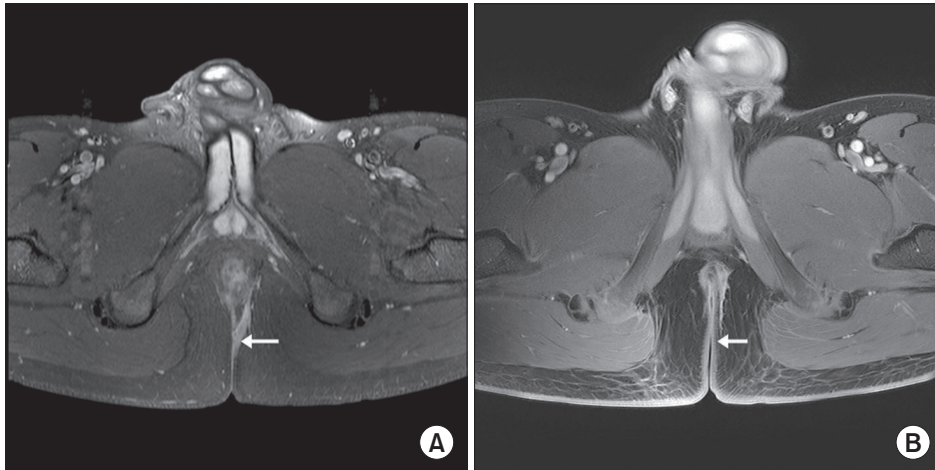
MRI shows a markedly obliterated fistula tract. (A) Before injection. (B) Six months after injection. The white arrows show the fistula tract.
